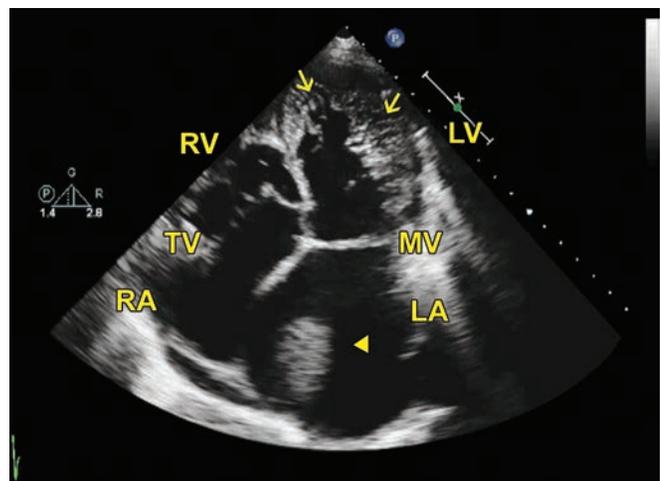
Apical 4-chamber view. Arrowhead shows a large mass in the left atrium.
